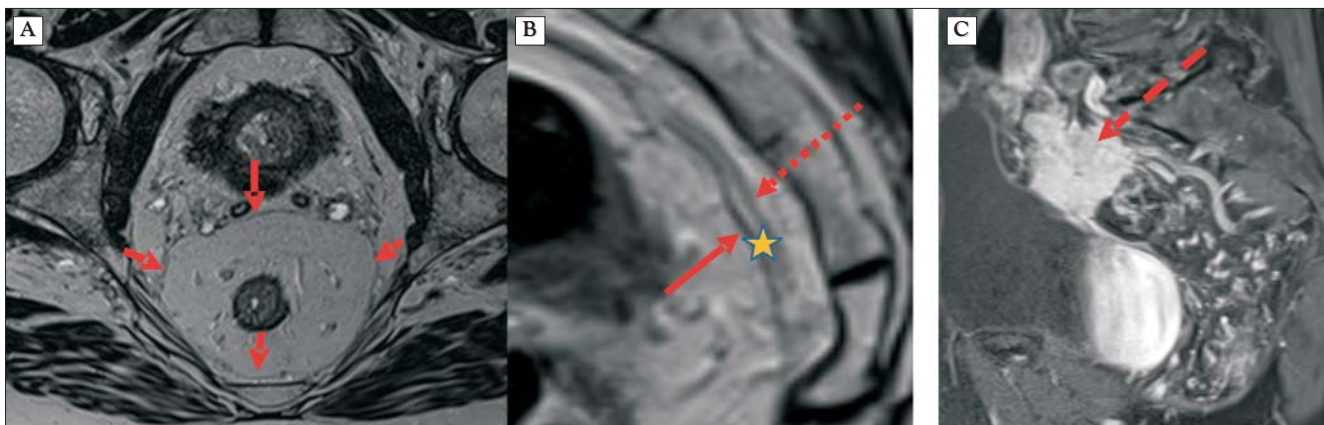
MRI presenting (A) the mesorectal fascia (arrows), (B) the clear avascular space (yellow star) where TME is performed, between the mesorectal fascia (normal arrow) and the pelvic fascia (interrupted arrow) and (C) a tumour (interrupted arrow) which invades the retrorectal space with the pelvic fascia and the presacral vessels, which means that TME is not possible.
